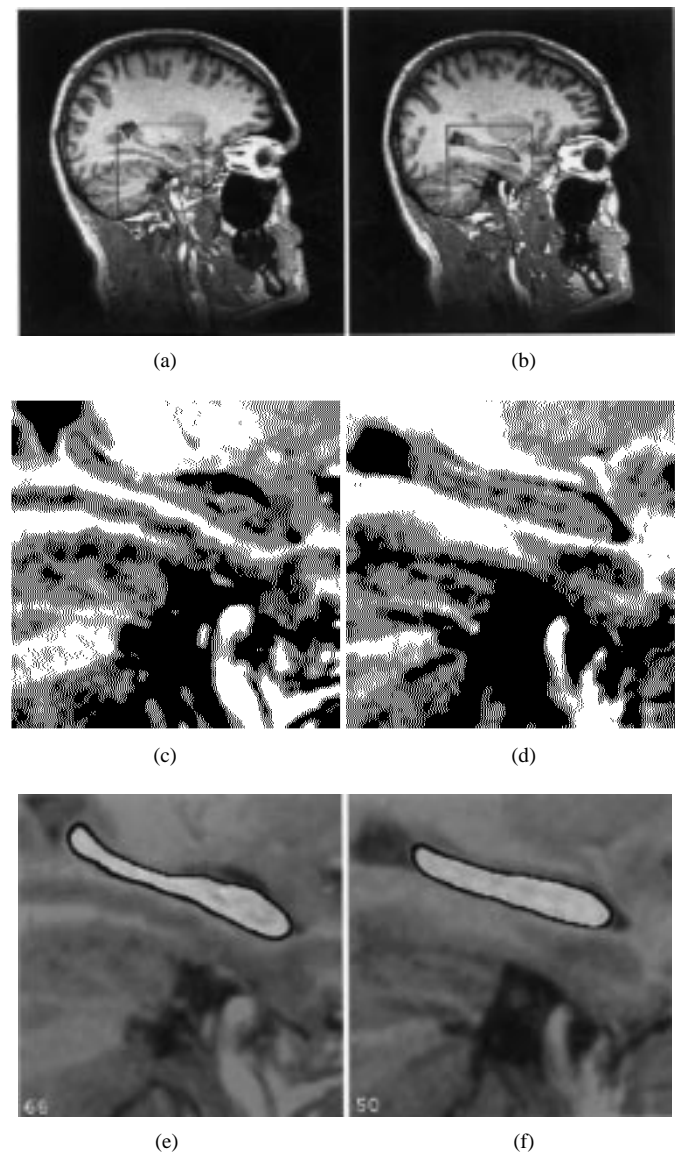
Sagittal cross section of MRI hippocampus template: (a) and (b) two slices of the MRI template where the hippocampus subvolume is shown in the red box; (c) and (d) the hippocampus subregion from (a) and (b) interpolated to 0.25^3 mm^3 resolution, respectively; (e) and (f) same as (c) and (d) with hippocampus segmentation superimposed, blue corresponds to everything but hippocampus.
